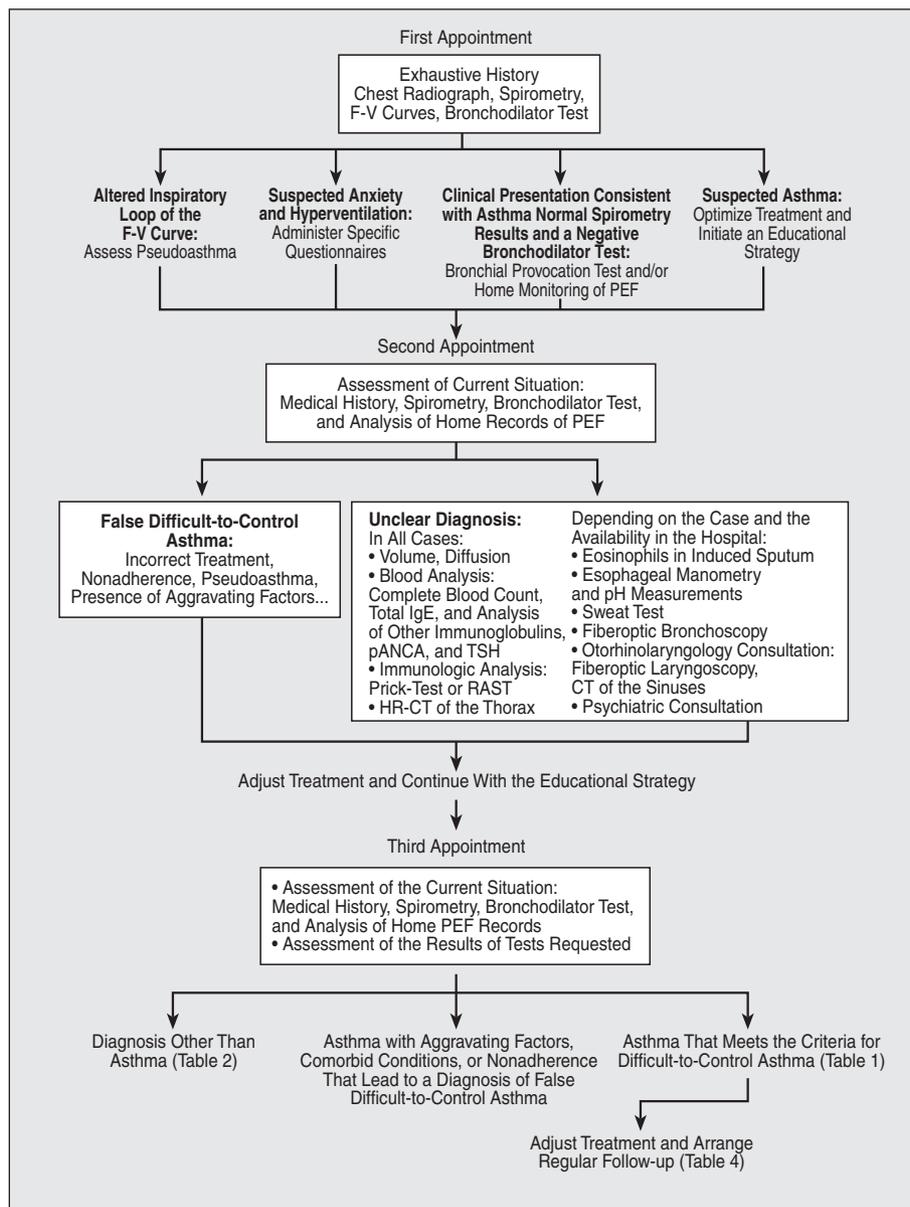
Action plan for medical appointments. F-V indicates flow/volume; PEF, peak expiratory flow; IgE, immunoglobulin E; pANCA, perinuclear antineutrophil cytoplasmic antibodies; RAST, radioallergosorbent test; CT, computed tomography; HR-CT, high-resolution CT; TSH, thyroid stimulating hormone.
